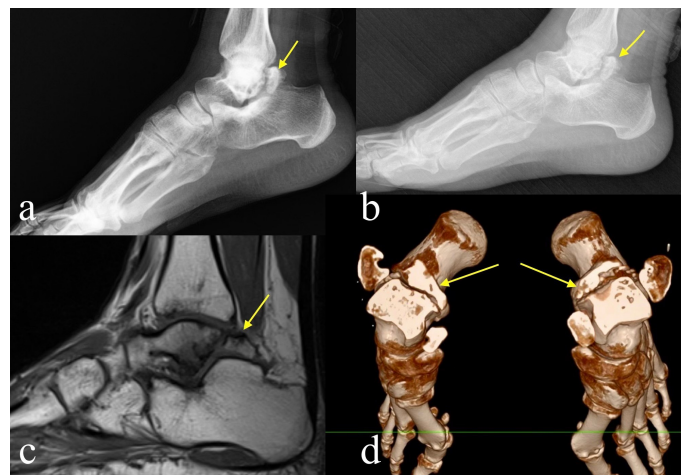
Right (a) and left (b) lateral foot radiography, magnetic resonance imaging (c) and three-dimensional tomography (d) images of bilateral complete symptomatic talus bipartition in a 30-year-old man.
